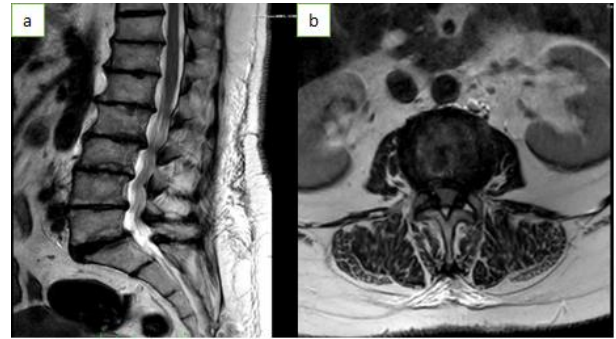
(a) Sagittal T2-weighted lumbar MRI showing narrowing of intervertebral disc spaces, multilevel osteophytic degeneration, spondylopathy, and grade 1 spondylolisthesis at the L5-S1 level, (b) axial T2-weighted lumbar MRI demonstrating spinal canal stenosis at the L2-L3 level.
